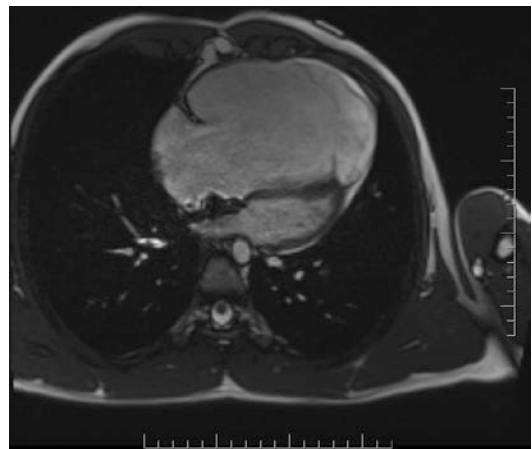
Cardiac magnetic resonance imaging of an Amplatzer device closure of an atrial septal defect in a patient with Ebstein anomaly
